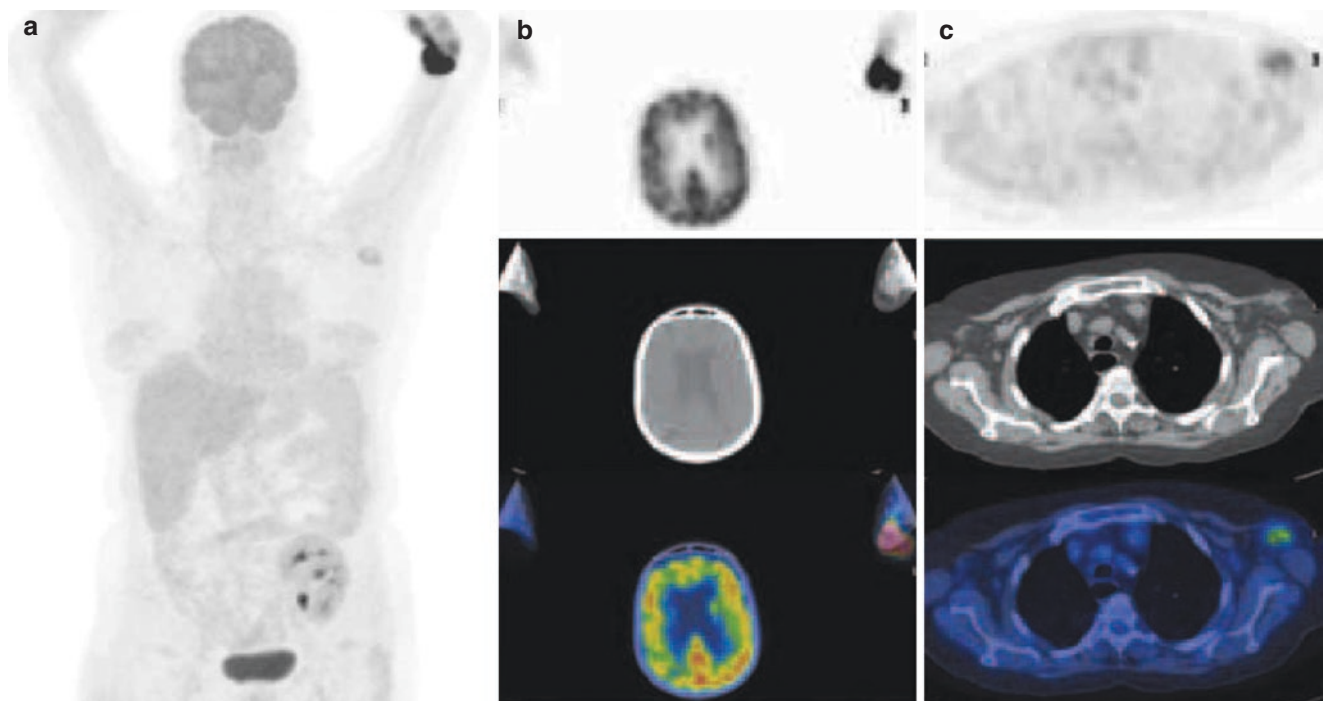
MIP [¹⁸F]FDG PET/CT image (a) shows intense radiopharmaceutical localization at injection site (left arm) as confirmed by transaxial views (b) associated with mild uptake in the left axilla (c) due to lymphatic drainage after [¹⁸F]FDG extravasation during administration
